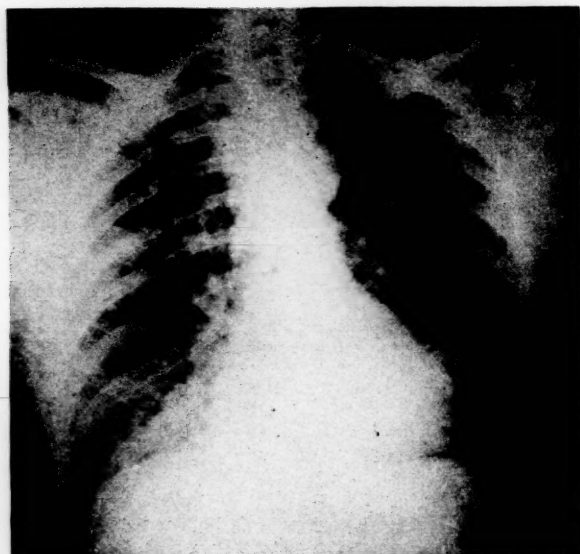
Case 1, chest x-ray taken on July 22nd, the day aureomycin treatment was started. Fairly extensive patchy infiltration of the right lung is evident.
